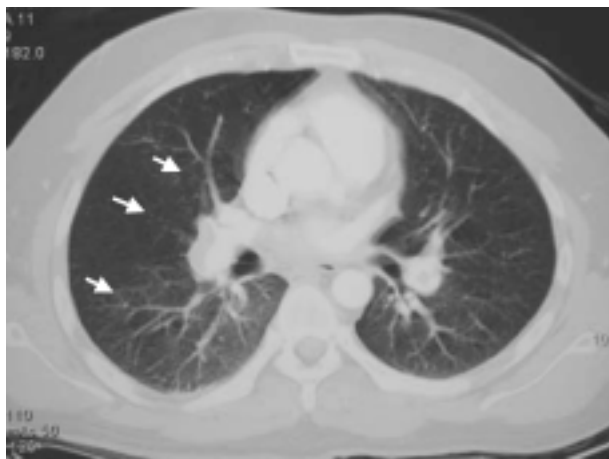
Multiple hypoperfused areas in the patient's right lung shown in the CT pulmonary angiogram (white arrows).
